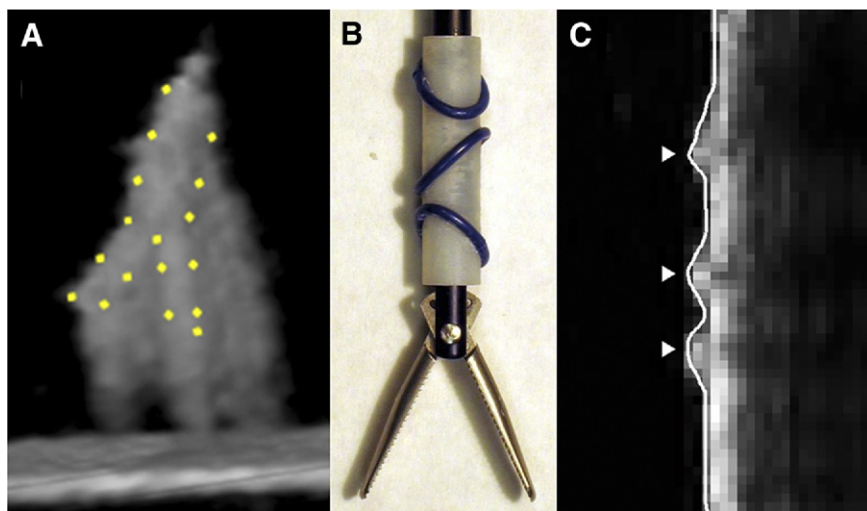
Ultrasound imaging of forceps. (A) Three-dimensional image of forceps with actual location indicated by dots. (B) Fiducial marker on shaft of forceps. (C) Ultrasound image showing detected locations of marker ridges (arrowheads). (Color version of figure is available online.)
